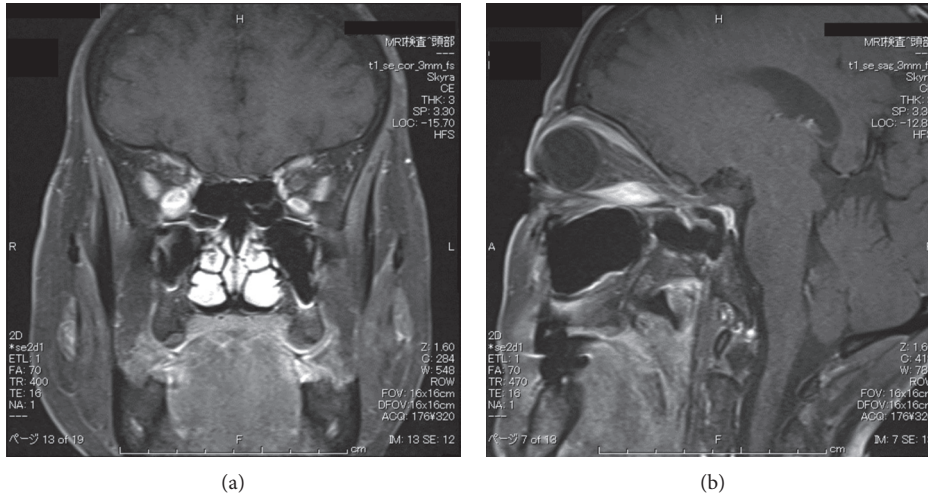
Magnetic resonance imaging revealing thickening of the right inferior rectus muscle (asterisk).
